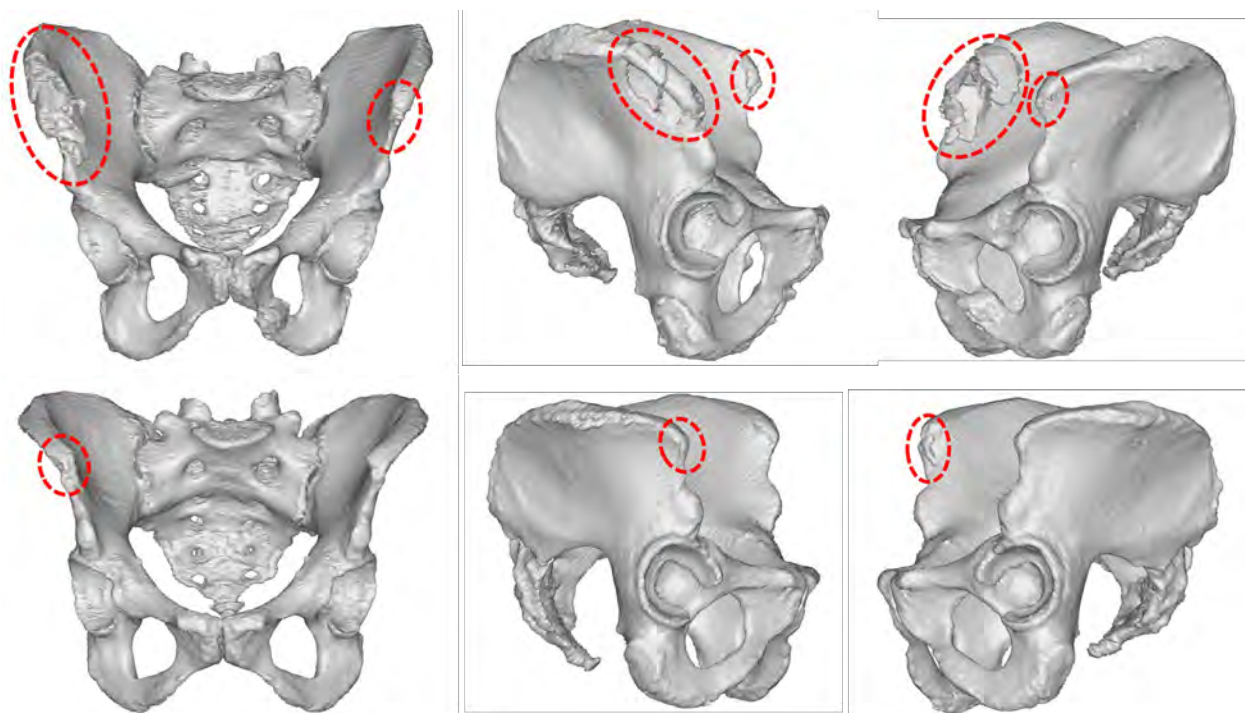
Reconstructed post-test pelvis CT scans from S0730/F1 (top row) and S0731/F2 (bottom row), showing the fractures at iliac wings near the ASIS landmarks in both subjects. A similar figure for the two fracture cases in the male tests can be found in Richardson et al. [38].
